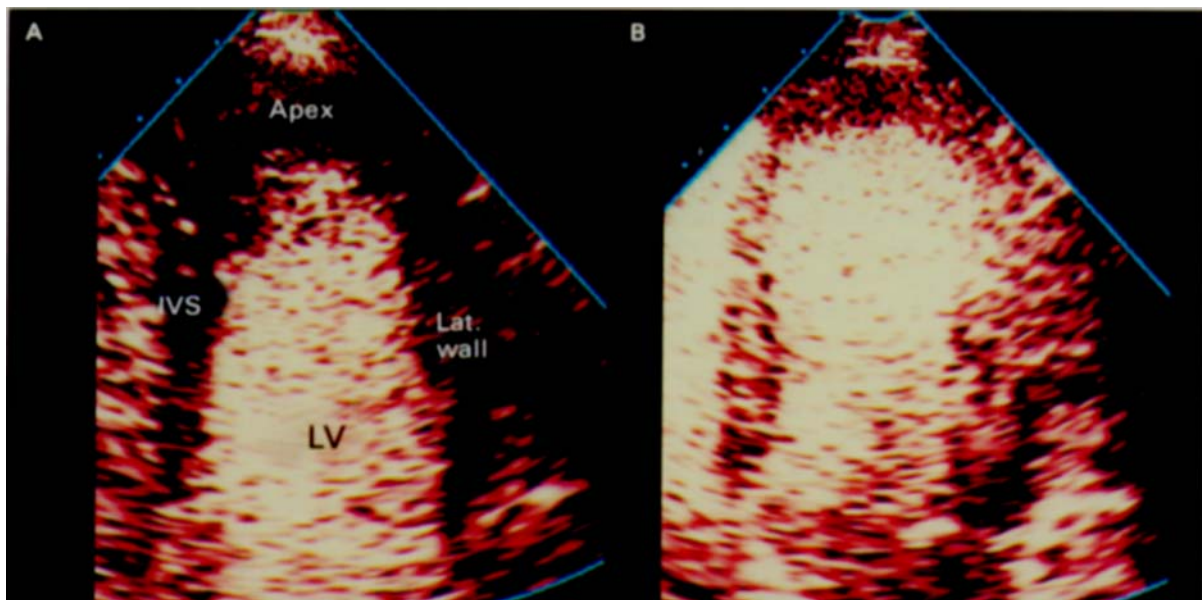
Myocardial contrast perfusion echocardiography. (A) Image of the left ventricle after peripheral venous bolus injection of ultrasound contrast agent (Optison® 0.3 ml followed by 10 ml saline) shows opacification of the left ventricular cavity. This allows assessment of wall motion and global systolic function, even in patients with poor image quality and/or dropouts of the endocardial borders. (B) After the injection, as the contrast agent passes through myocardial capillaries, the myocardium also becomes opacified. The intensity of the ultrasound reflected from the myocardium depends on the amount of microbubbles present in the microcirculation, and consequently on myocardial blood volume and perfusion. The changes in contrast density with time (wash-in and wash-out) are related to myocardial blood flow velocity and can be measured by video densitometry in selected regions of interest. IVS = interventricular septum, Lat. wall = lateral wall, LV = left ventricle. (Image courtesy of Dr. Michel Zuber, Kantonsspital Lucerne, Switzerland.)
